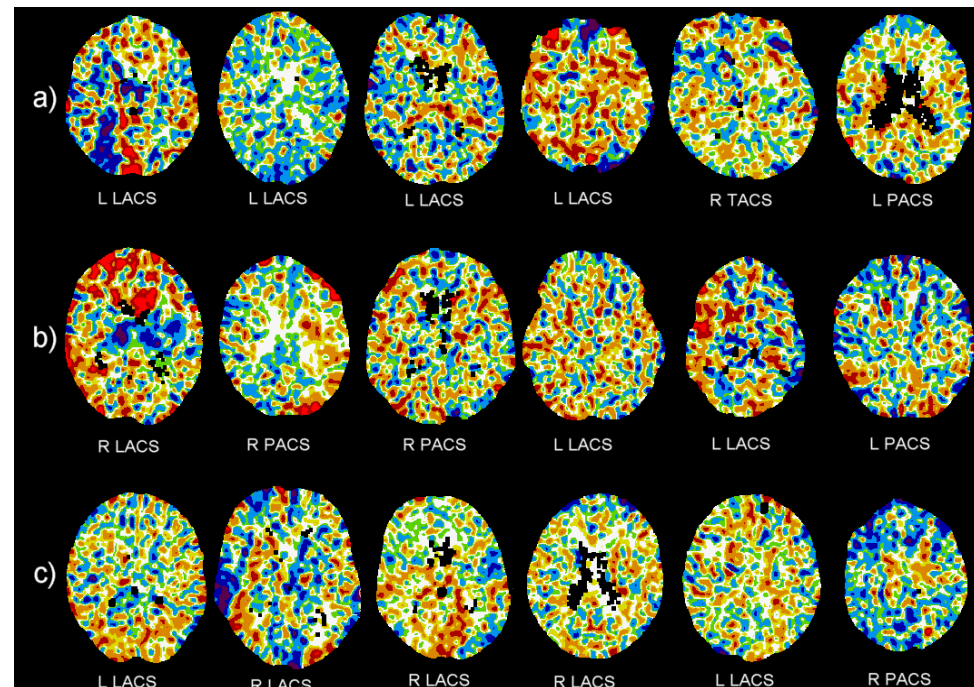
CBF difference scans (post GTN – baseline) for all patients. Patients receiving active treatment: rows a) and b); control: row c). Axial slices are shown at the level of the largest lesion diameter, or an appropriate level for the clinical presentation if no lesion was visible on the CT scan. The side of lesion (R: right; L: left) and Oxfordshire Community Stroke Project classification (LACS: lacunar syndrome; PACS: partial anterior circulation syndrome; TACS: total anterior circulation syndrome) is given for each scan.
